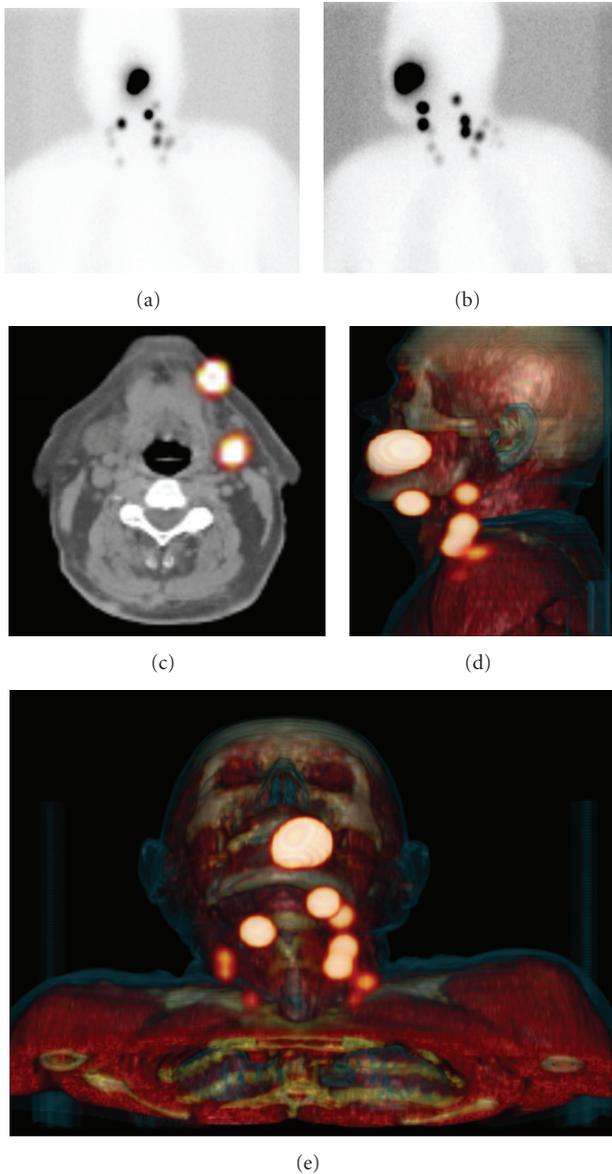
SPECT/CT localizing sentinel nodes and providing anatomic overview. Anterior (a) and oblique (b) planar static images after 2 hours show several hotspots. Two-dimensional SPECT/CT reconstruction exactly localizes each node, for example, localizing 2 sentinel nodes in the submandibular region (c). Three-dimensional SPECT/CT reconstruction shows an anatomic overview of all sentinel nodes (d) and (e).
